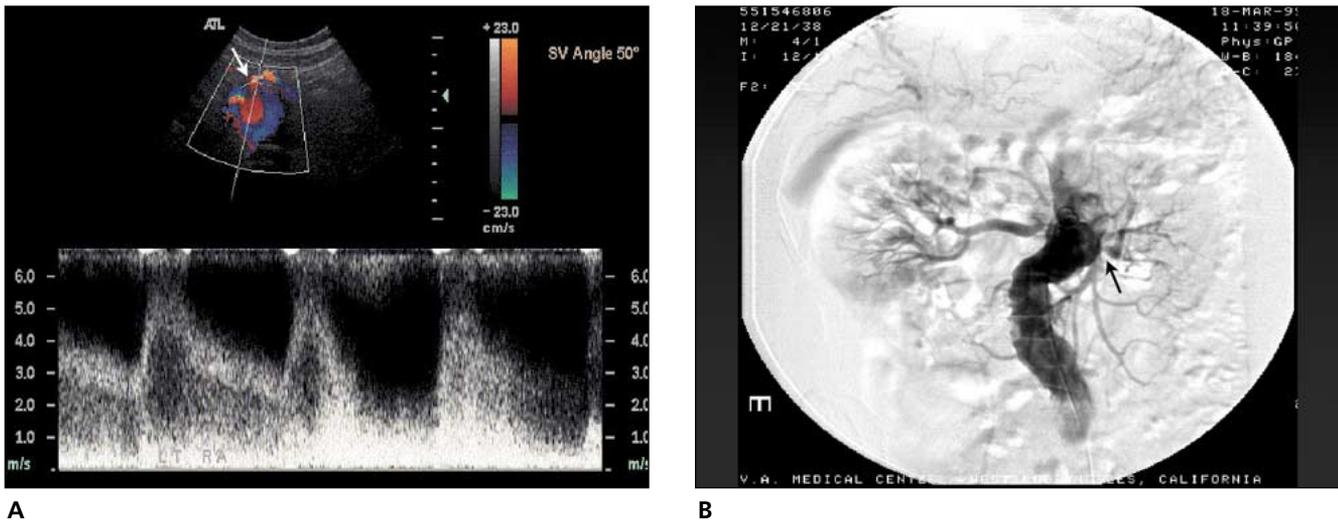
A, Spectral Doppler image of the left renal ostium showing marked velocity elevation compatible with RA stenosis. As a result of aortic tortuosity, the left RA (arrow) is found originating anteriorly off the aorta. The right RA arose almost directly posteriorly (not shown). B, Abdominal aortogram confirming the sonographic findings. Note the marked tortuosity of the aorta and the unusual angulation of RAs requiring oblique imaging to display the ostial areas. The arrow points to the left renal ostial stenosis. Note that the right RA origin is also narrowed.
